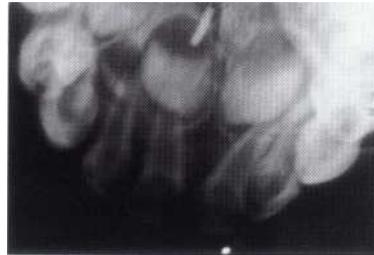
Radiograph of a patient with nursing bottle syndrome. The teeth are vital and sufficient root structure exists to salvage them.
